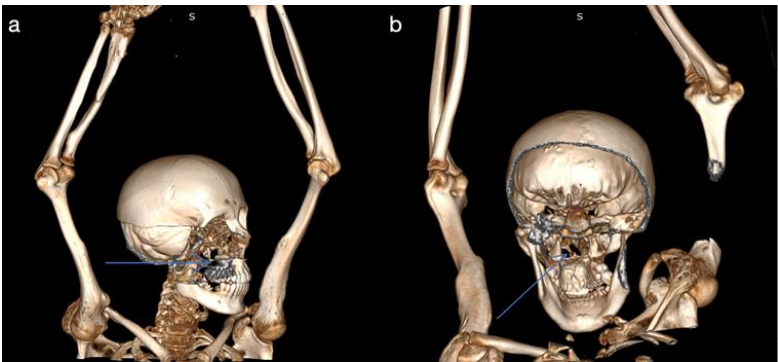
CT appearance of an enchondroma located in the vomer bone- destruction of the vomer bone: a. lateral view, b. posterior view.
